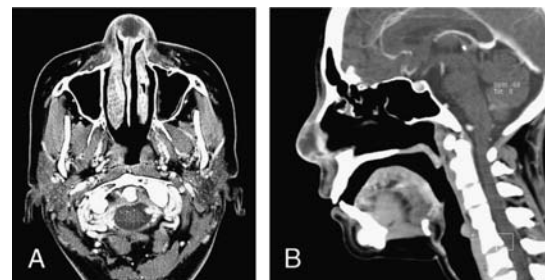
Facial computed tomography (A, B) imaging demonstrates a thin-walled, cystlike collection with peripheral enhancement involving the cartilaginous septum consistent with a nasal septal abscess.
